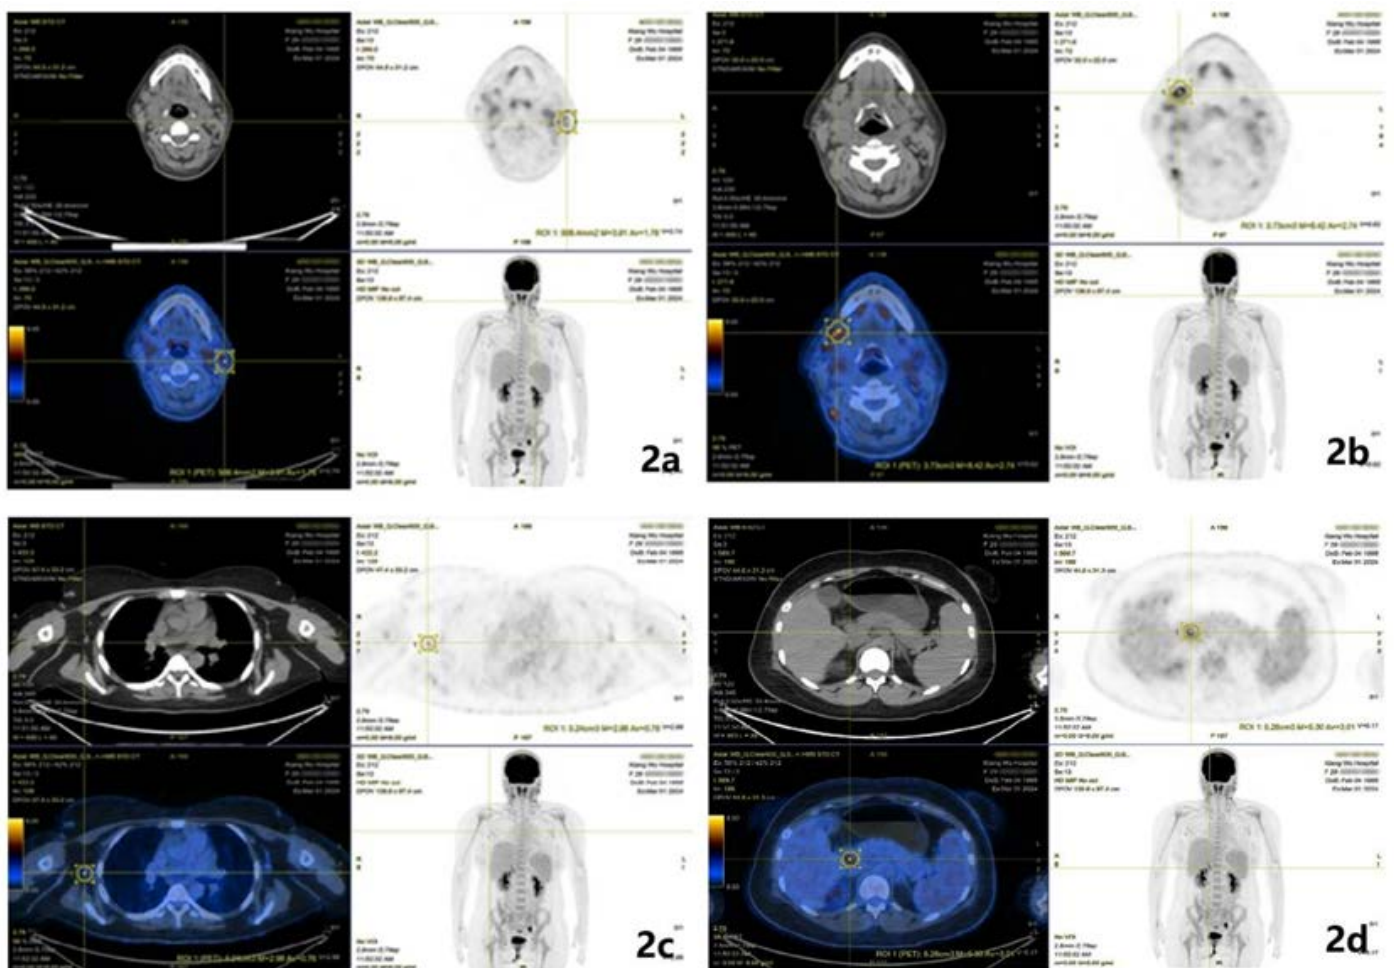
A 29-year-old woman with BPDCCN underwent an 18F-FDG PET/CT examination, which revealed multiple active lymph nodes throughout the body with an SUVmax ranging from 1.8 to 8.4.
